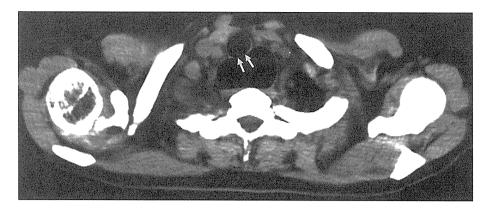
Computed tomography of the chest after balloon dilatation of the lower esophageal sphincter. The dilated esophagus was located adjacent to the membranous part of the trachea (arrows).
